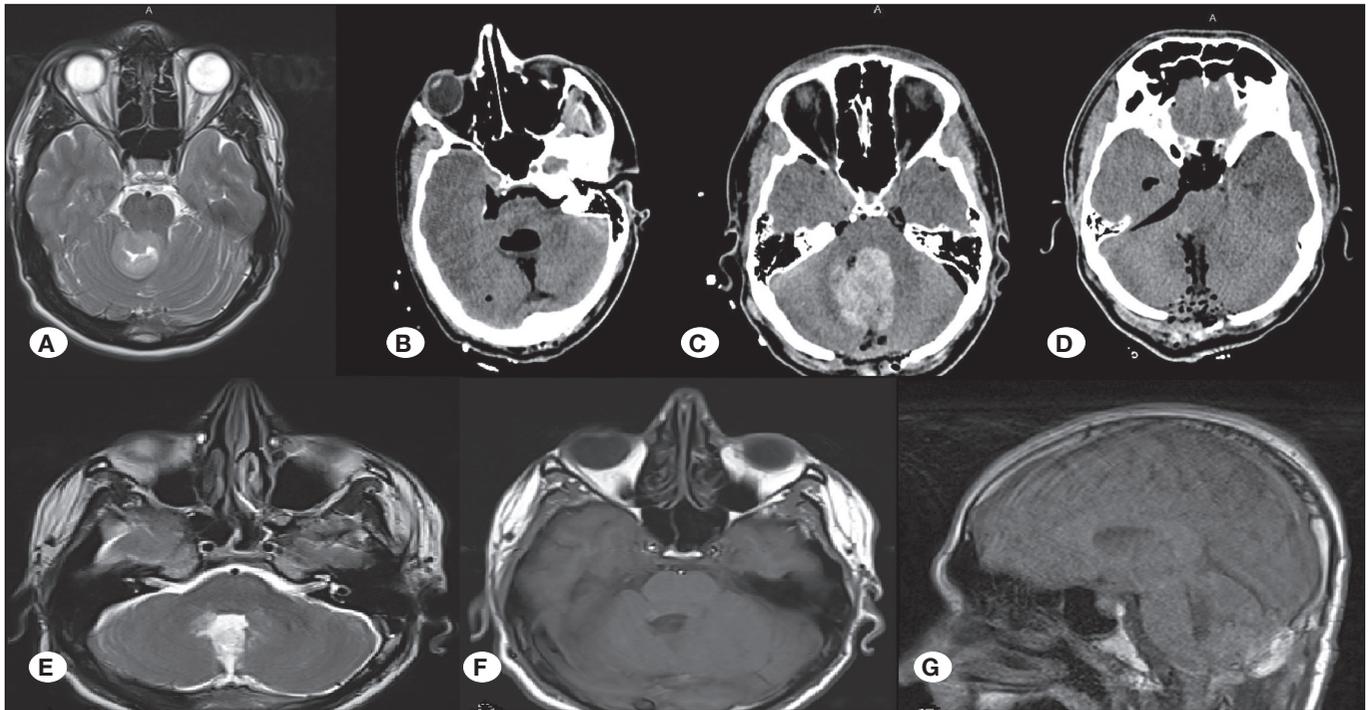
A) The axial section of the cranial T2W magnetic resonance imaging (MRI) shows a midline cerebellar mass with brainstem invasion. B) A postoperative early-stage cranial computed tomography (CT) reveals that the mass has been totally excised. C) The second CT scan after the seizure showing intraventricular hemorrhage. D) A follow-up CT scan of the patient who had undergone repeat surgery. A follow-up cranial MRI scan performed 1 month after surgery reveals that the mass has been totally excised (E: axial T2W, F: axial T1W contrast enhanced, G: sagittal T1W contrast enhanced).
